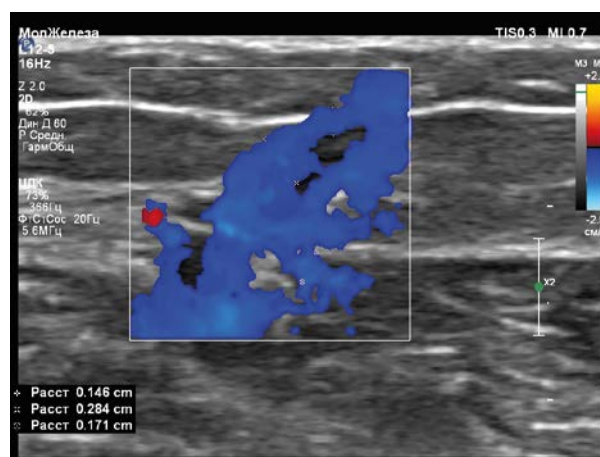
Branched network of perforant veins in magnification mode with color Doppler mapping of blood flow, measurement of tributary diameters ($D=0.1$ cm, $D=0.2$ cm, $D=0.3$ cm).
